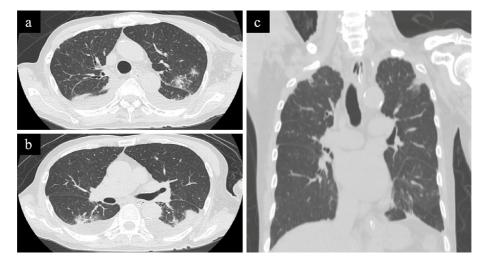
Follow-up CT (day 11). a) Axial view: Lower thoracic esophagus. The mediastinal emphysema had disappeared, as had the emphysema in the neck of the esophagus. b) Axial view: All emphysema in the mediastinum had disappeared. c) Coronal view: All emphysema in the mediastinum had disappeared.
